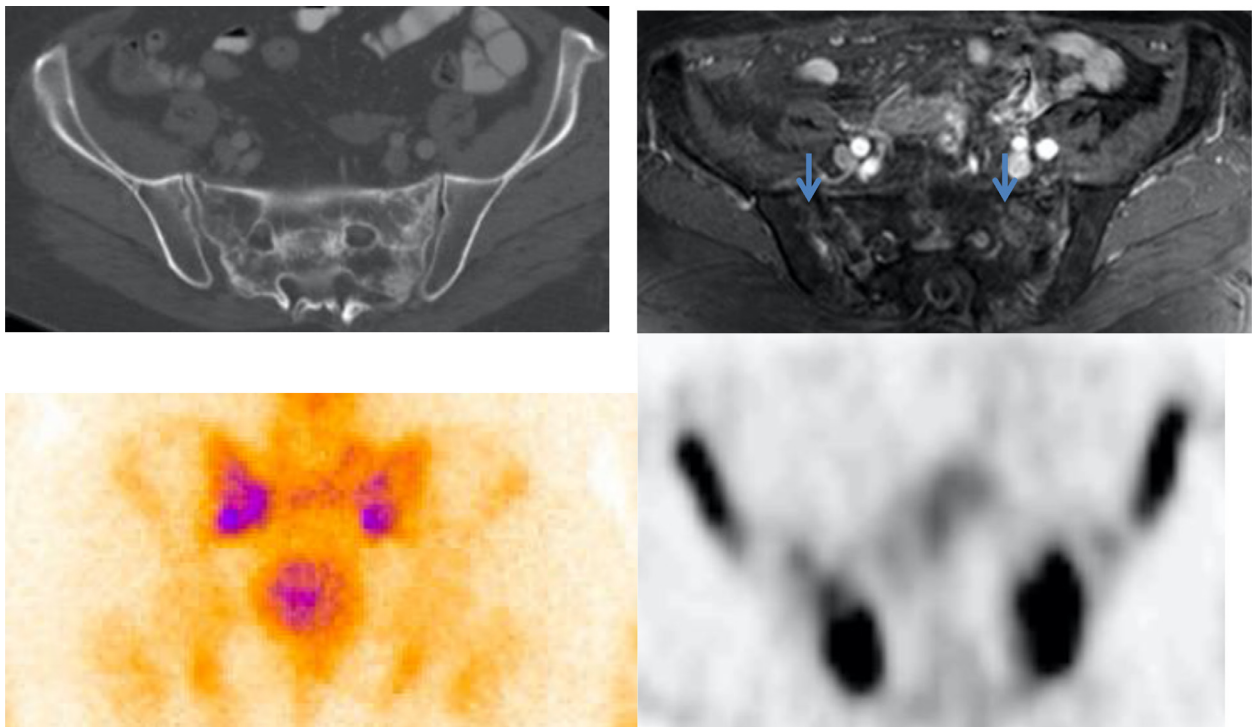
Case 3. Follow-up CT showed inhomogenous sclerosis without visible fracture lines. Follow-up MRI showed slightly increased contrast material accumulation in sacrum (blue arrows). Tc-99m MDP accumulation in sacrum lateral sides was seen on bone scan images. (Color version of figure is available online.)
